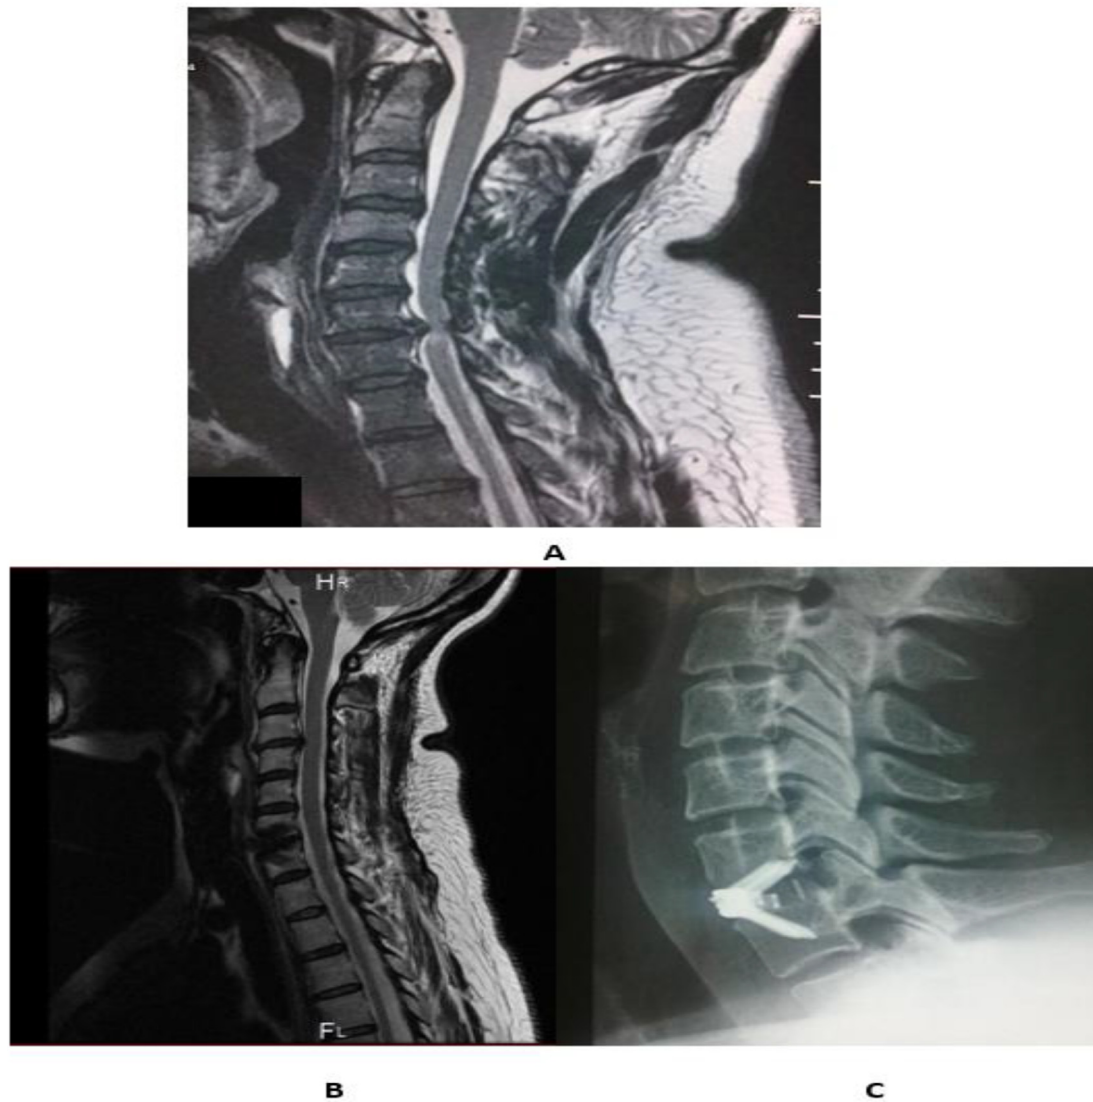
(A) Preoperative MRI cervical spine T2 sagittal view showed C6–7 disc prolapse with cord signal; (B) postoperative MRI cervical spine T2 sagittal view showed excision of the herniated disc, decompression of cord, and no cord signal; (C) plain radiography of cervical spine lateral view showed stability of cervical spine, fusion, and in-place cervical cage.
